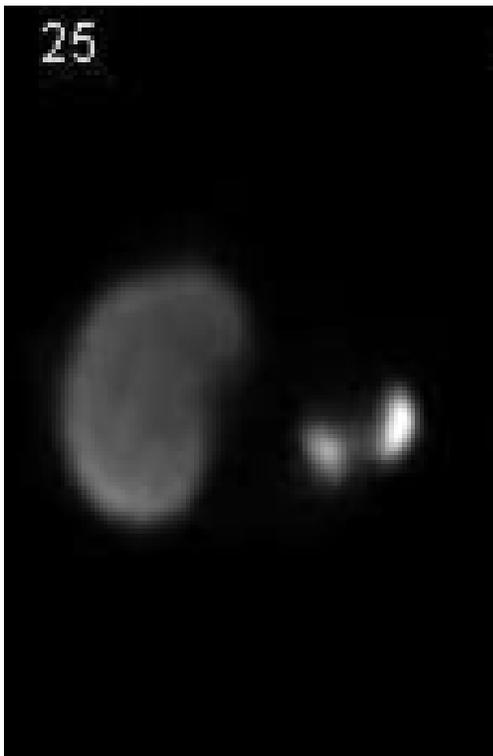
A 70 year-old thyroid cancer (differentiated papillary follicular) patient with well controlled (HbA1c 5.8%) type 2 diabetes mellitus (BMI 24.3) is post thyroidectomy and I-131 ablation of thyroid remnants with a negative thyroid cancer scan shortly before the SPECT liver spleen scan shown. She has had mildly suppressed TSH, e.g. 0.194 mIU/ml with (normal 0.45-4.50 mIU/ml) and has had osteoporosis. Her Sn value was 1.41, significantly (3.8 standard deviations) > normal Sn 0.956+0.120. The degree of heterogeneity in her liver (axial SPECT above, left) is difficult to appreciate without quantitative analysis. Log plots for positive (above right) and negative (above left) slopes were used to determine Sn and Sw with a linear fit for Sn and a binomial fit for Sw. The normalization factor to multiply by Sb to get Sn was: $(2)(\text{BMI}/23)[(\text{Liver span})/15][\text{Liver AP diameter}]/(14.58)[(\text{Spleen span})/(7.2)][13.5/\text{ECF}][1.6/\text{BSA}]$. Of interest, the negative slope Sw = -1.549 even more sensitively detects abnormality vs. normal Sw 0.933+0.099, being 6.22 standard deviations from normal.
